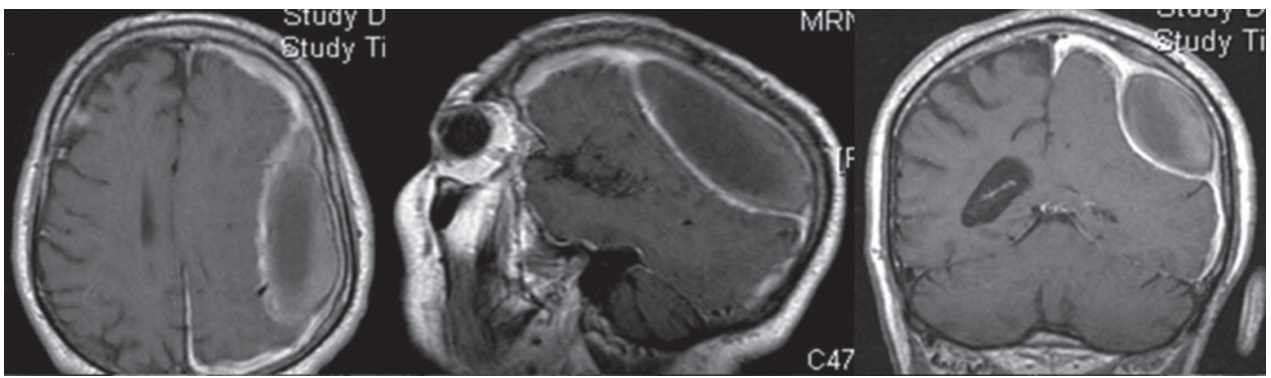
Axial, sagittal, and coronal preoperative magnetic resonance images with gadolinium, showing a left fronto-parietal lesion apparently located in the epidural space and compressing the underlying brain with left lateral ventricle distortion and severe mass effect on the surrounding brain. Cerebral sulcations are no more visible and leptomeningeal enhancement is observed along the entire left hemisphere.
